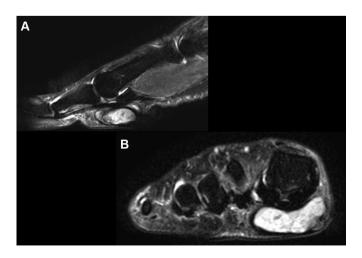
Cystic lesion at the plantar surface is well depicted as a high signal intensity lesion on T2 fat-saturated sequence magnetic resonance imaging: (A) sagittal view; (B) coronal view.
